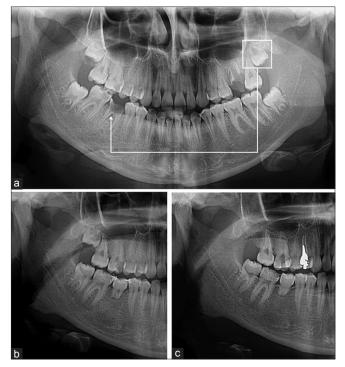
Patient's panoramic radiographs showing the case just before surgery and procedural planning (a), 8 months postsurgery (b), and follow-up after 4 years (c)
